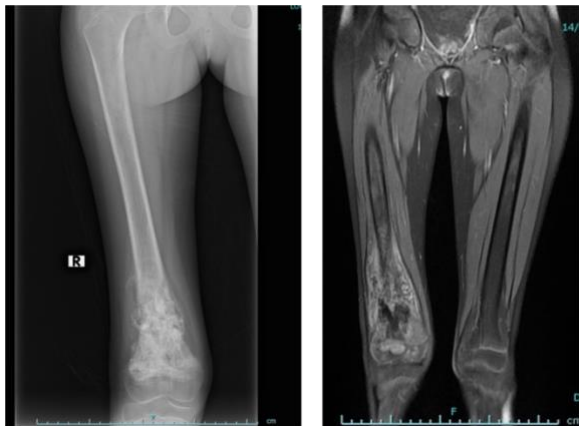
Pre-op X-ray and MRI of patient 1 showing distal femur malignant lesion with pathological fracture and soft tissue mass
